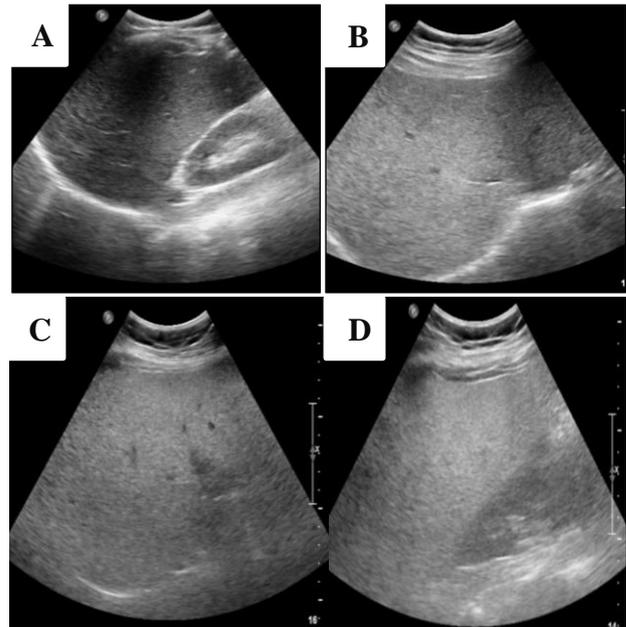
Grey scale sonographic image of normal liver and various grades of fatty liver. A) Grade 0/normal, B) Grade I, C) Grade II, D) Grade III.
